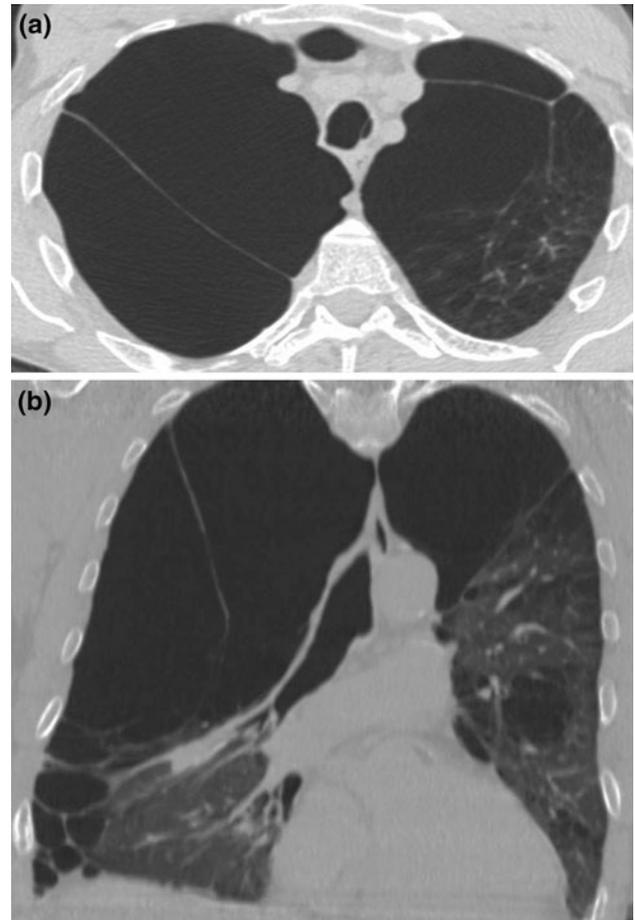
Bullous emphysema in a 29-year-old male cocaine smoker with dyspnea. Chest HRCT images (a, b) show large bullous formations in the upper lobes
